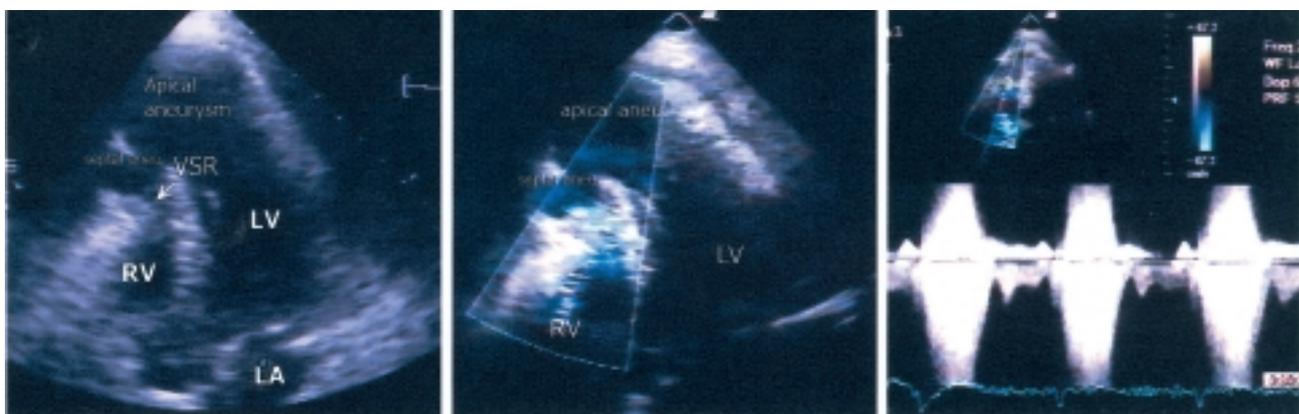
Transthoracic echocardiography performed at the time of the second admission revealed that there was a rupture of the distal ventricular septum. Left panel: two-dimensional echocardiographic image of the apical 5-chamber view. A large apical aneurysm was shown; the distal part of the ventricular septum was thin and dyskinetic, it was dilated and, similar to a septal aneurysm, bulged towards the right ventricle (RV) during systole. There was a small (arrow) dehiscence of the myocardium at the center of the septal aneurysm. Middle panel: color Doppler echocardiography of the same view reveals a turbulent jet (bright blue) across the defect and entering into the RV. Right panel: continuous wave Doppler shows the systolic jet across the defect. LA = left atrium; LV = left ventricle; VSR = ventricular septal rupture.
